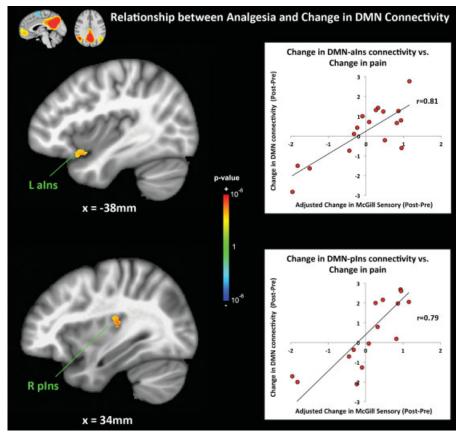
Relationship between changes in age-adjusted clinical pain and intrinsic default mode network (DMN) in patients with fibromyalgia. Multiple linear regression analysis demonstrated that the change in age-adjusted clinical pain at the time of functional magnetic resonance imaging correlated with reduced intrinsic DMN connectivity to the left anterior insula (L aIns). A subthreshold cluster was also found in the right posterior insula (R pIns).
